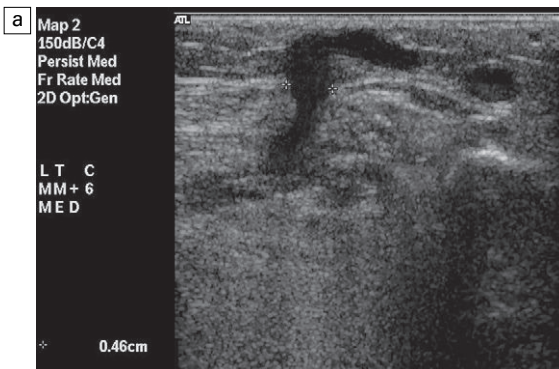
(a) An incompetent calf perforating vein with a diameter of approximately 5 mm passing through the superficial fascia; (b) colour Doppler shows flow passing from the deep to the superficial veins.
